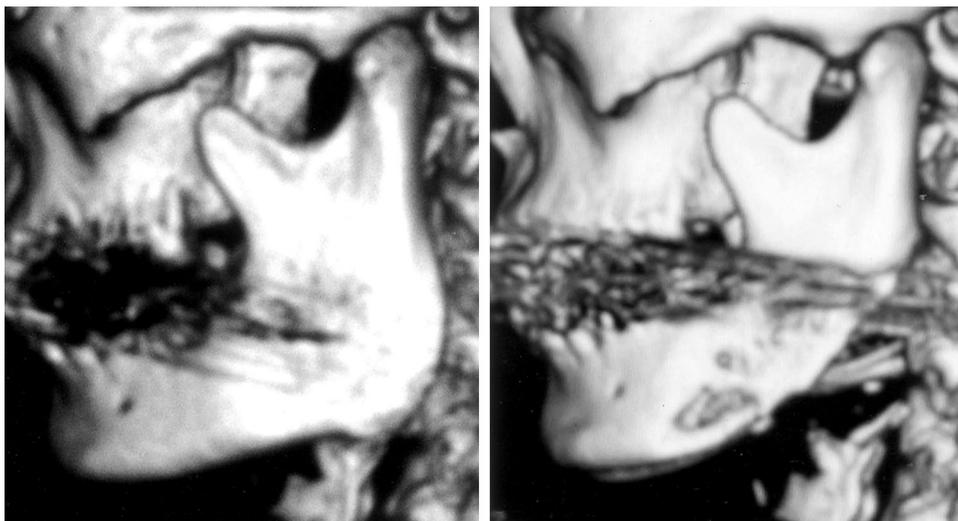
The patient in case 3, a 51-year-old woman. (*Left*) Preoperative three-dimensional computed tomographic scan reveals remarkable hypertrophic angle of the mandible. (*Right*) Postoperative three-dimensional computed tomographic scan shows that the osteotomy was effective.
